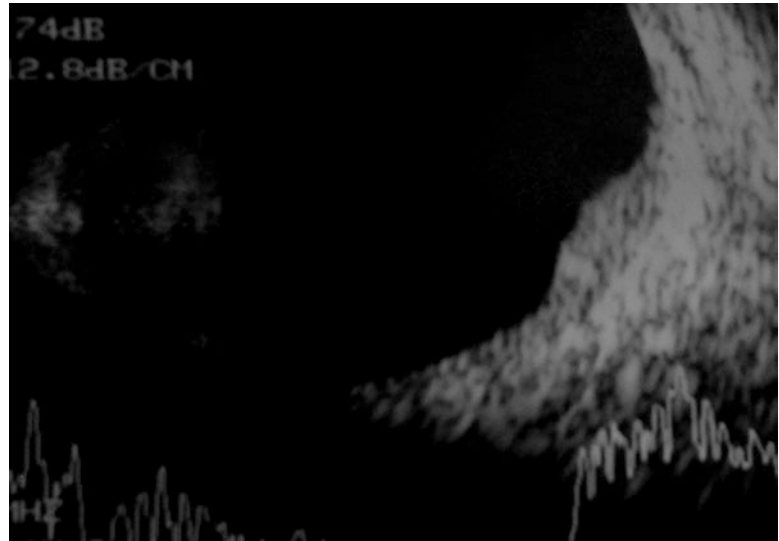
(a) Fundus image of a pigmented elevated mass lesion suggestive of a melanoma. (b) Ultrasound A&B scan of the mass showing a mushroom-shaped solid lesion arising from the choroid, suggestive of a melanoma
